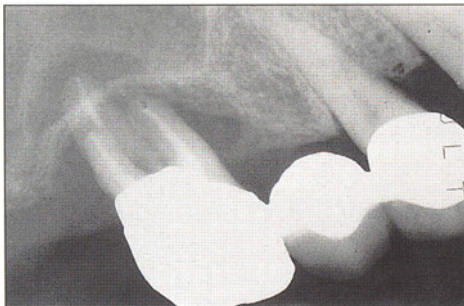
Preoperative radiograph. Severe bone resorption of the alveolus is apparent in the molar area. The sinus is at the level of the bone crest.
